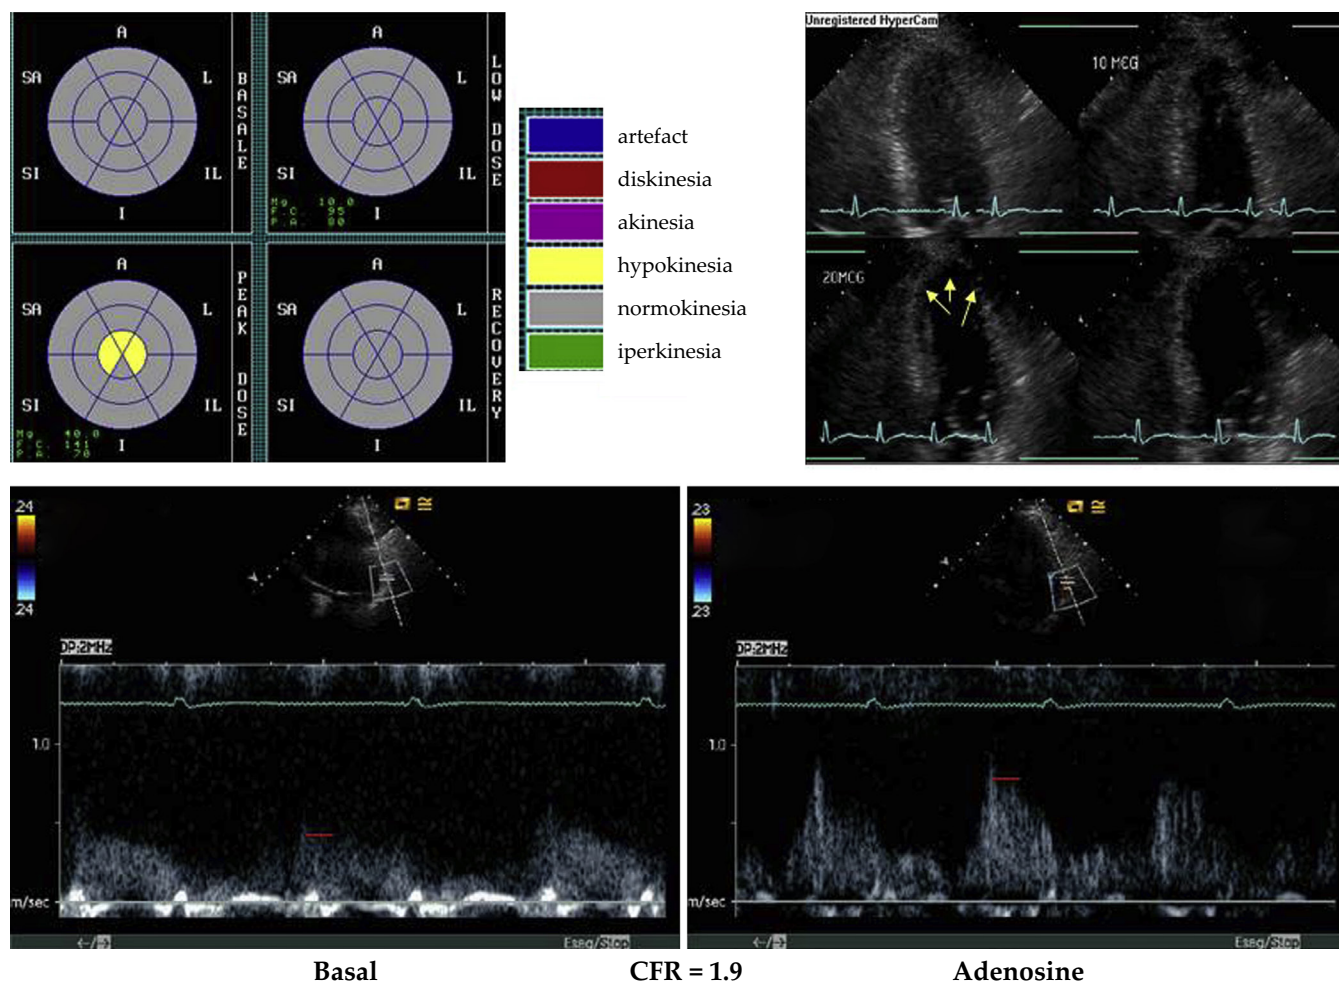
Doppler echocardiography image of a SSc patient with wall motion abnormalities (hypokinesia of apical segments) during Dobutamine Stress Echocardiography (upper panel) and abnormal Coronary Flow Reserve (lower panel). Adapted from Vacca et al. [133].
